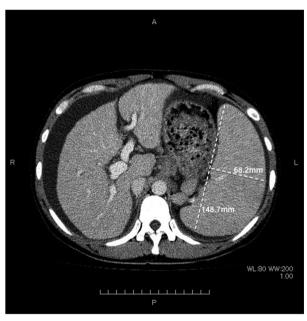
Computed tomography scan of the abdomen showing massive ascites and striking splenomegaly. The volume was 1152 cm³, which was calculated based on methods proposed by Kucybała et al [11].
